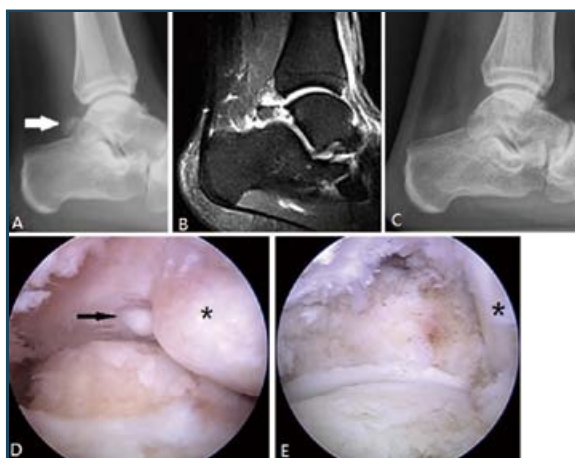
Endoscopic excision of an os trigonum. A: X-ray revealing a large os trigonum posterior to the talus. B: MRI (STIR sequence) demonstrating increase in signal of the os trigonum with fluid and synovitis. C: Post-op X-ray after excision of the os trigonum. D: Endoscopic view showing a loose body (Arrow) on the left side of the os trigonum (*). E: The os trigonum was excised (Flexor hallucis longus tendon (*)).
